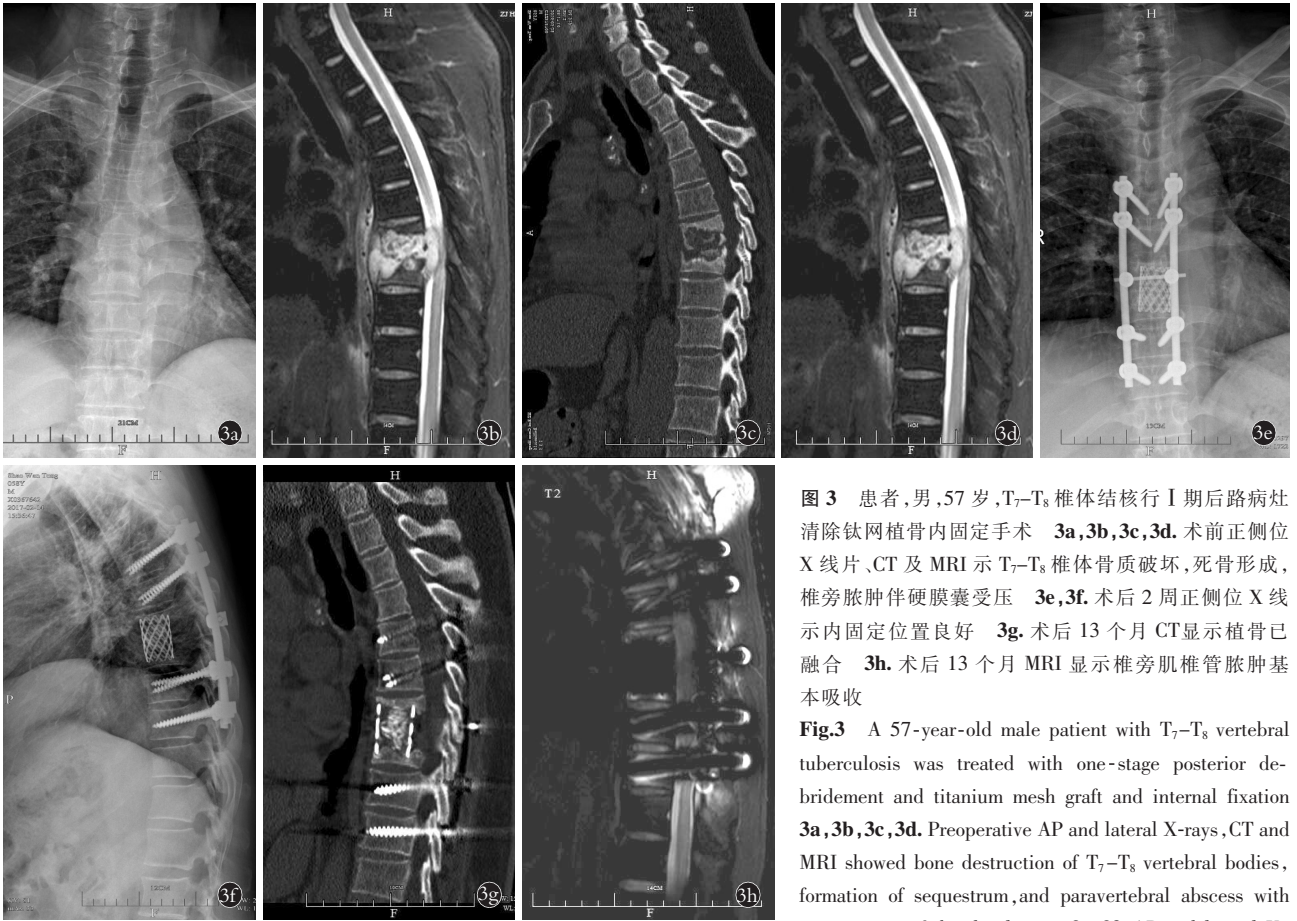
患者,男,57岁,T₇-T₈椎体结核行 I 期后路病灶清除钛网植骨内固定手术 3a,3b,3c,3d。术前正侧位 X 线片、CT 及 MRI 示 T₇-T₈椎体骨质破坏,死骨形成,椎旁脓肿伴硬膜囊受压 3e,3f。术后 2 周正侧位 X 线示内固定位置良好 3g。术后 13 个月 CT 显示植骨已融合 3h。术后 13 个月 MRI 显示椎旁肌椎管脓肿基本吸收
